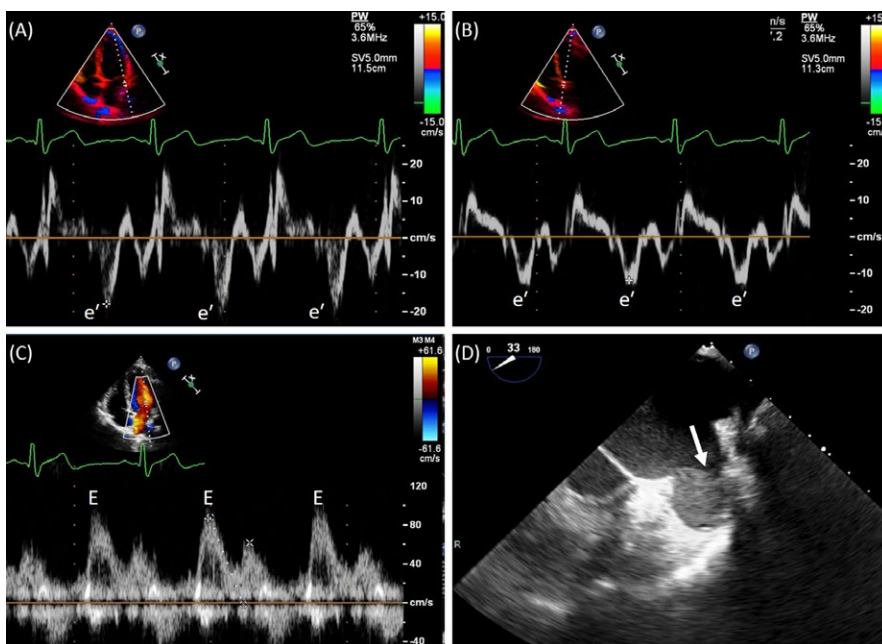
Representative images highlighting transthoracic and transesophageal echocardiogram measurements. Tissue Doppler recording lateral (A) and medial (B) e' measurements. Pulsed-wave Doppler recording of mitral inflow velocity (C). Left atrial appendage thrombus (D - arrow)
